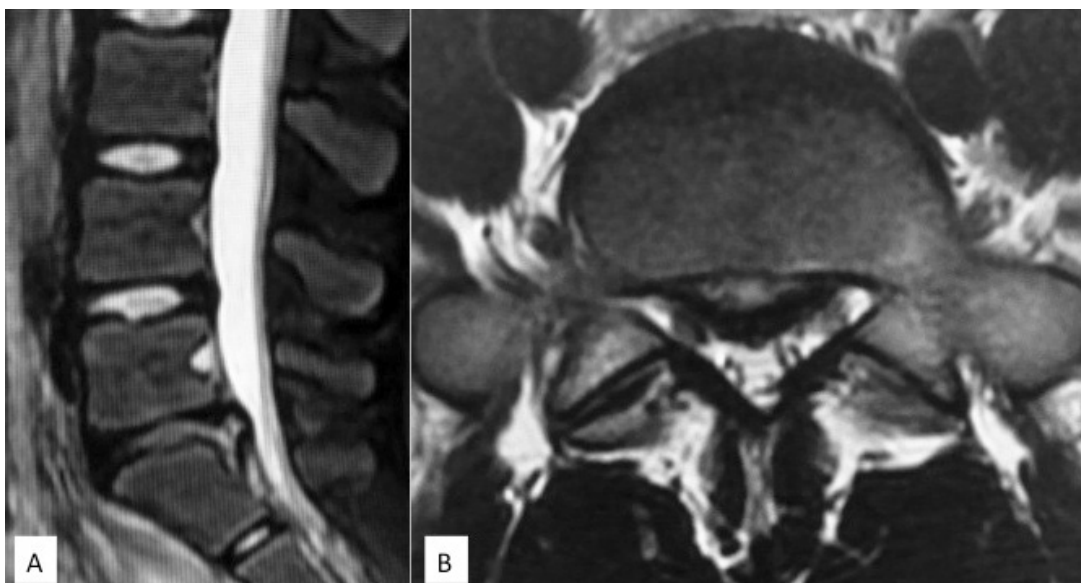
Magnetic resonance image showing severe central L5/S1 disc protrusions
